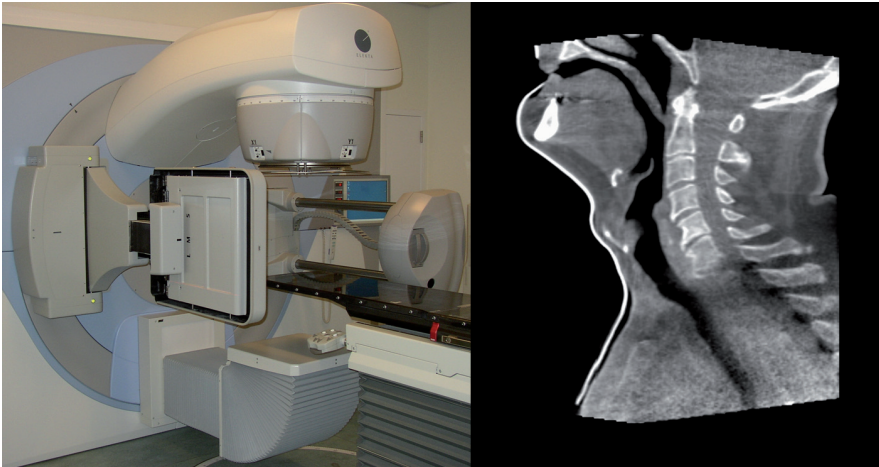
Left panel: the Elekta Synergy system with an additional kV tube and 2D detector for acquisition of cone-beam CT-scans and the Theraview NT EPID for set-up verification and dosimetric QA; Right panel: sagittal cone beam CT-slice for a H&N patient.
